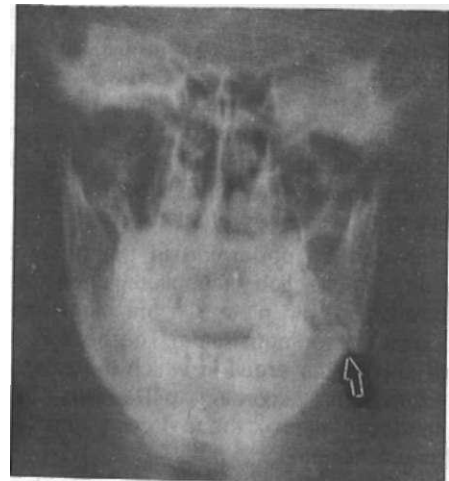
A fracture line in the left angle and right corpus of the mandible in an X-ray taken from one of our patients.
